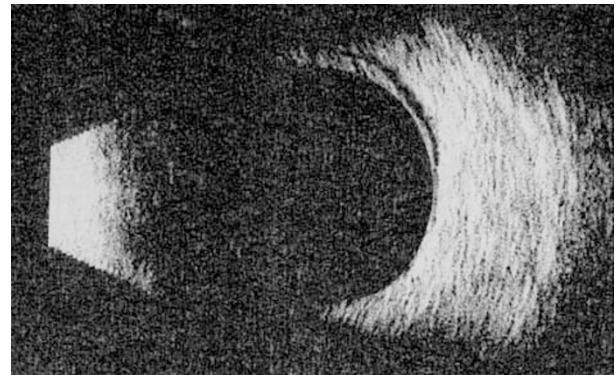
B-Scan ultrasound of the left eye confirming choroidal haemorrhage.
